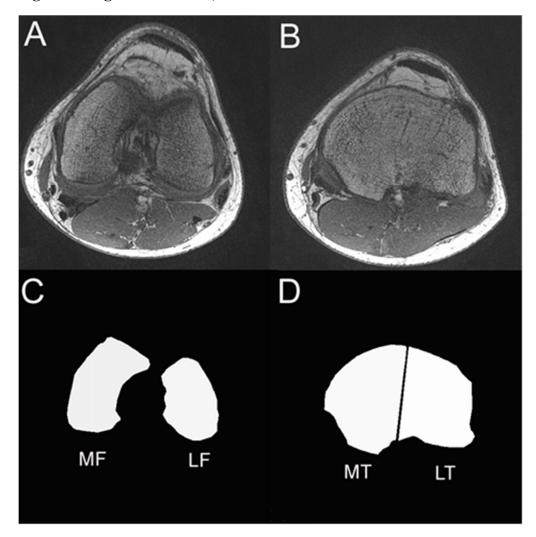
Representative MR images of the left knee of a subject with neutral knee alignment: distal femur (A), proximal tibia (B) and their correspondingly segmented compartments MF: medial femur and LF: lateral femur (C); MT: medial tibia and LT: lateral tibia (D).
